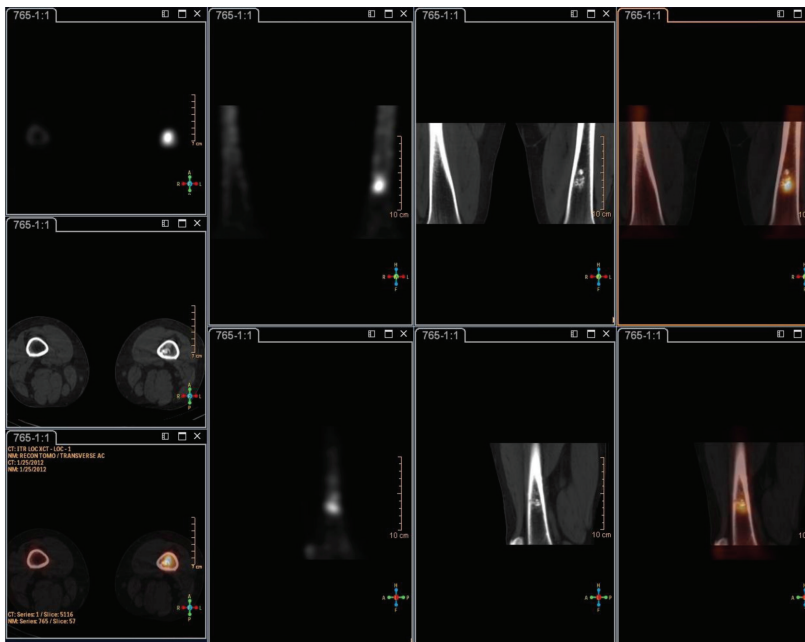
SPECT/CT of distal femurs show focal intense uptake within the bone marrow with some calcification, more likely benign.
